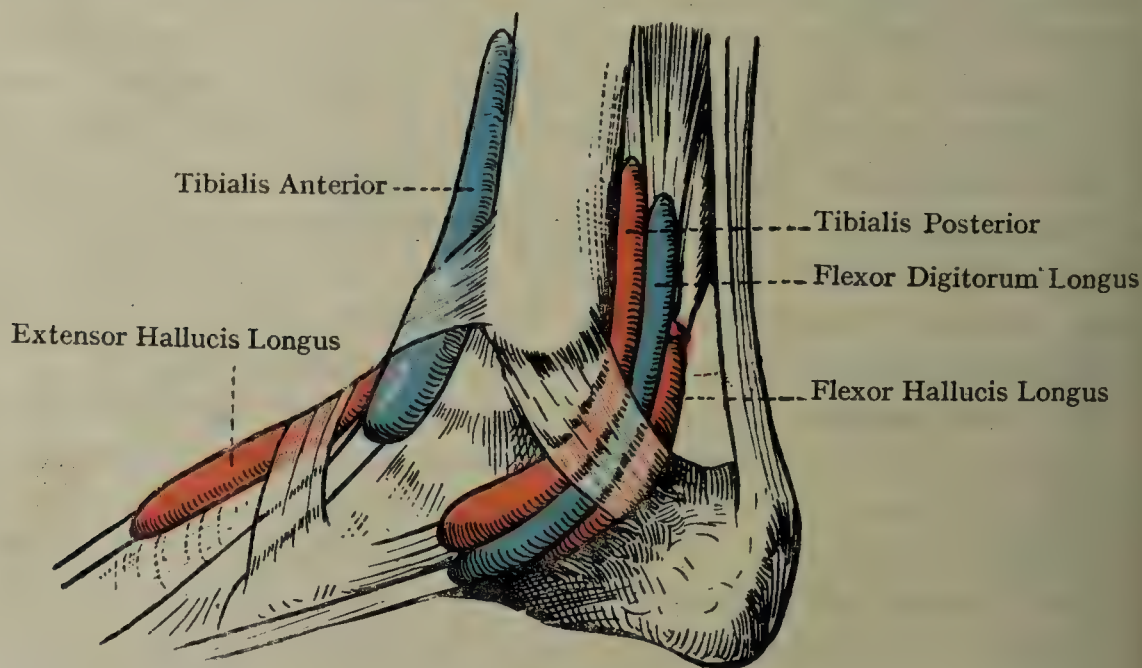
THE SYNOVIAL SHEATHS AT THE ANKLE (MEDIAL ASPECT)
